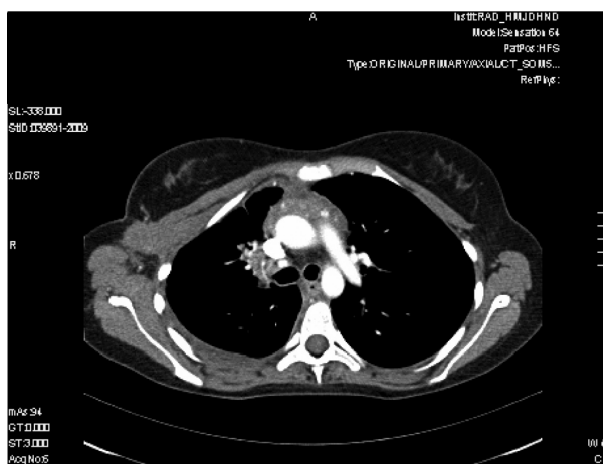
Computed tomograph scan of thorax-abdomen, March 7, 2009. Wide prevascular mediastinal involvement.
